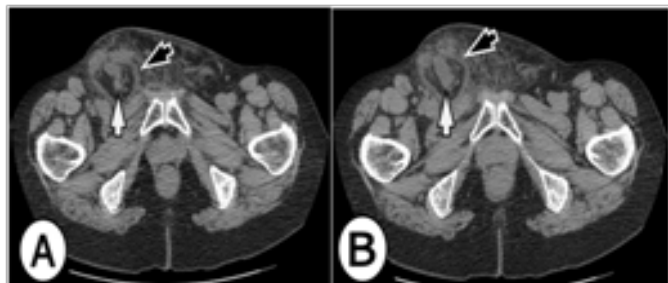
69-year-old female with right-sided Amyand's hernia. CT scans of the abdomen (A) and (B): Axial CT scan at the level of inguinal regions shows an inflamed appendix (white arrow) extends into the small right inguinal hernia (black arrow). There were no signs of obstruction or strangulation.
